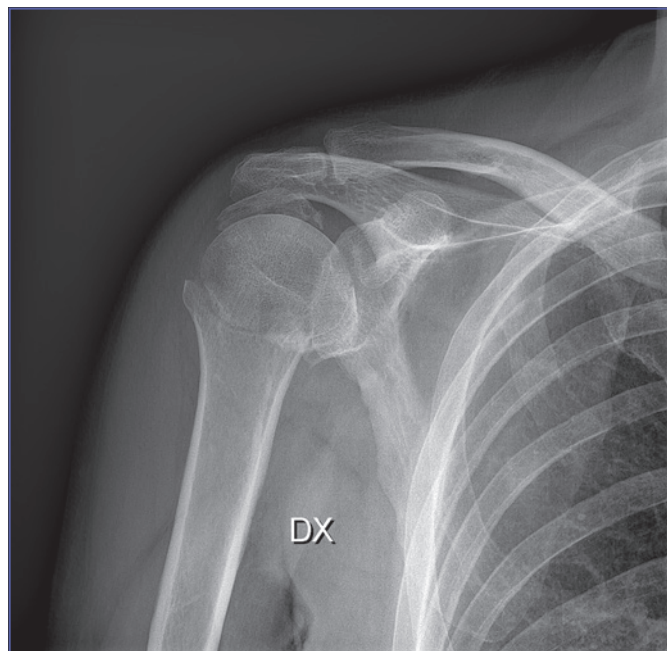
Male, 61 years old, preoperative X-ray.
